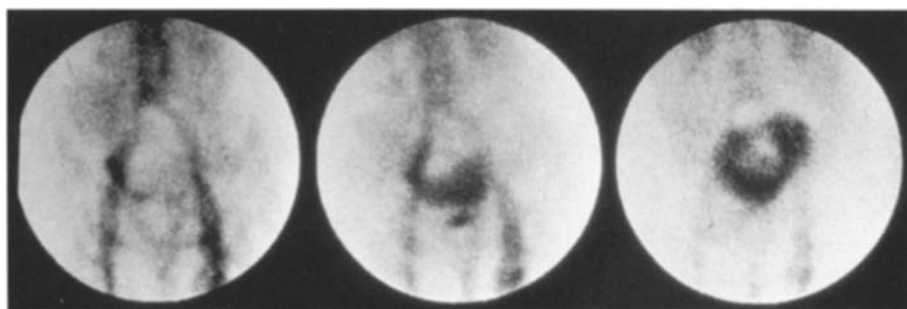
Radioimmunoscintigraphy with ^{99m}Tc -SM3 monoclonal antibody against a stripped mucin core glycoprotein antigen at: *left* 10 min; *centre* 6 h; *right* 22 h; anterior views in a patient with ovarian cystadenocarcinoma. Specific tumour uptake increases with time around a focal defect due to the cyst (courtesy of Dr. Granowska)
